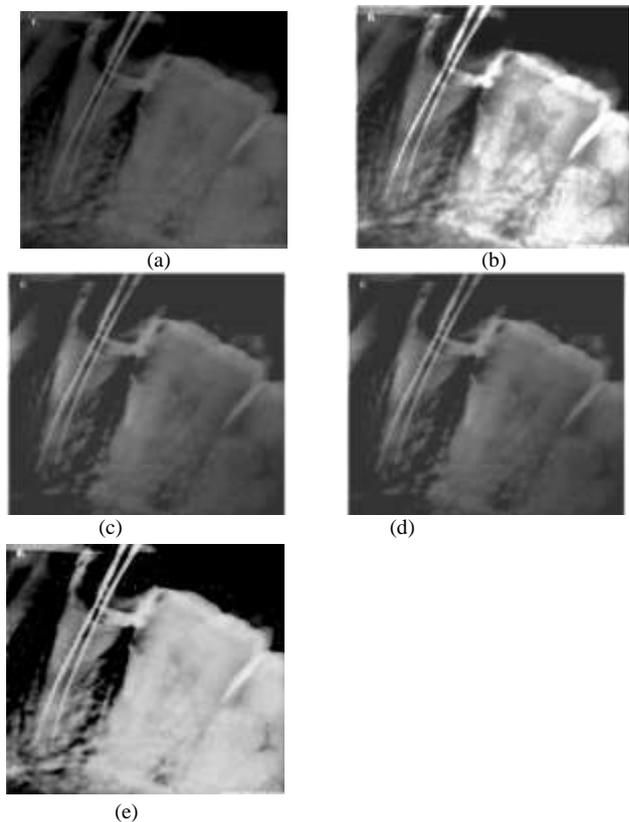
(a) Decayed tooth with double root CBCT input image (b) Output image after Histogram (c) Output image after CLAHE (d) Output after MSR (e) Output after Fuzzy enhancement.
